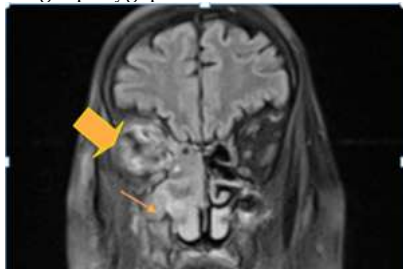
MRI brain (FLAIR coronal section) shows soft tissue thickening in the right maxillary sinus with extension to the right nasal cavity (Arrow) and right orbit (Bold Arrow). Intraconal and extraconal fat stranding in the right orbit with premaxillary edema.
